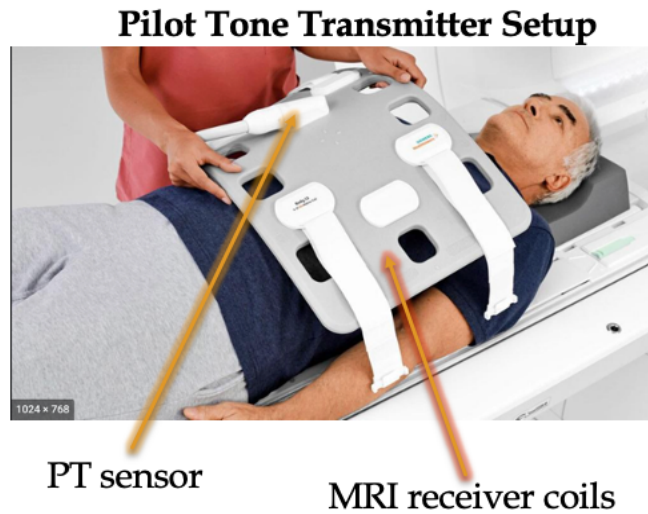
PT transmitter setup for subject prior to an MRI scan.
